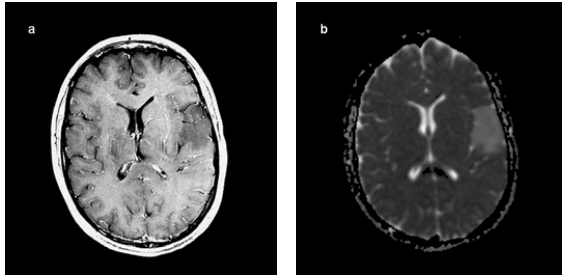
Low-grade astrocytoma (WHO grade II) in a 32-year-old woman. a Post-contrast T1-weighted image shows a slightly hypointense lesion and no enhancement in the left temporal lobe. b ADC map (minimum ADC tumor value) shows hyperintensity in the lesion ($1.30 \times 10^{-3} \text{ mm}^2/\text{sec}$).
